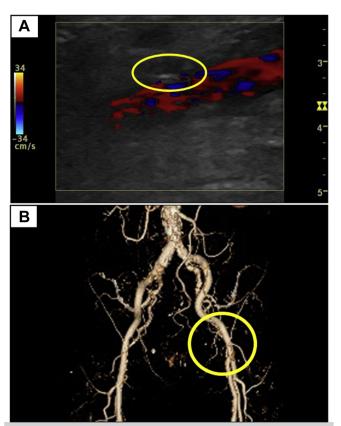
A, Vascular ultrasound findings the day after hemostasis. The *circle* indicates the collagen plug of Angio-Seal at the wall of the left common femoral artery (CFA). B, Three-dimensional computed tomography angiography (3D-CTA) after 8 months. The *circle* indicates no evidence of recurrence.
